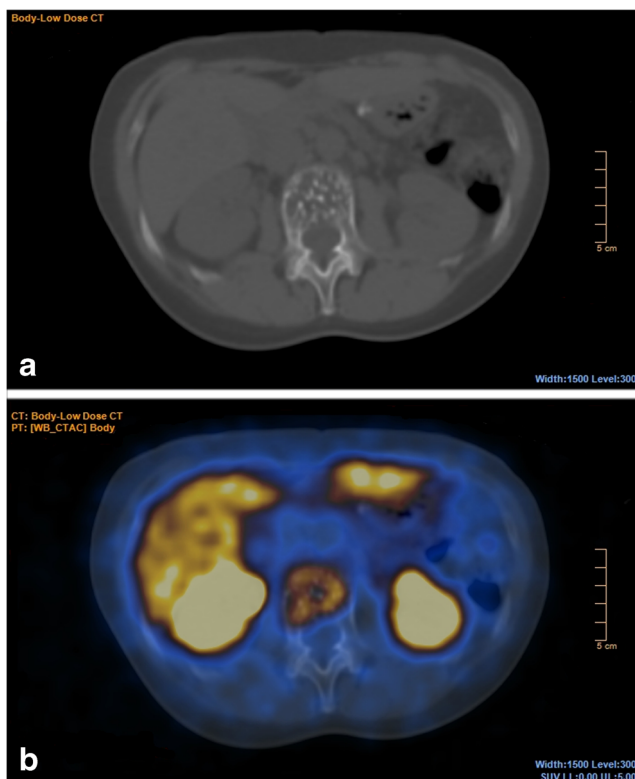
Axial CT and fusion images centred on a typical vertebral haemangioma of L2 showing an intense DOTA-TOC uptake ($SUV_{max}=8.0$, SUV_{max} ratio to reference vertebra=8.4, to liver=0.49, to spleen=0.17) and the ‘polka dot’ pattern on CT, in a 60-year-old woman referred for initial workup of a pancreatic neuroendocrine tumour (NET)
